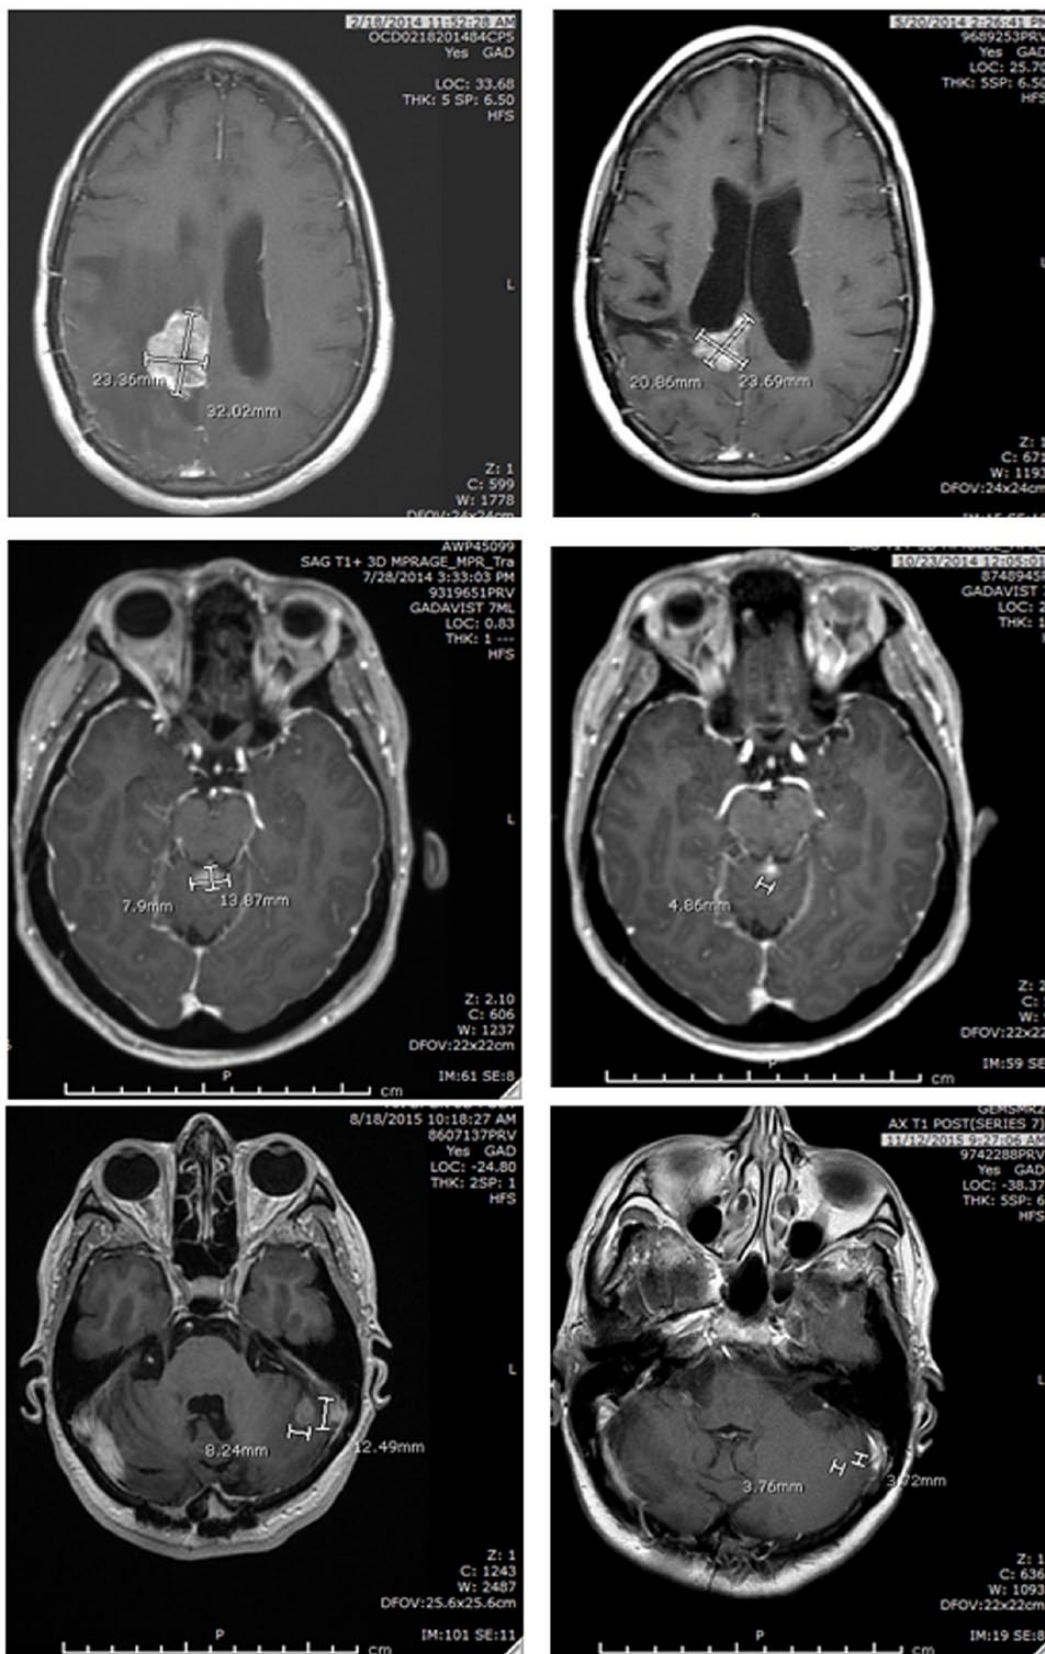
Magnetic resonance imaging showing partial response in three patients at the 12-week timepoint. Left panel: baseline; right panel: 12 weeks after therapy. All patients initiated therapy with capecitabine 750mg/m², everolimus 10mg and lapatinib 1000mg.
